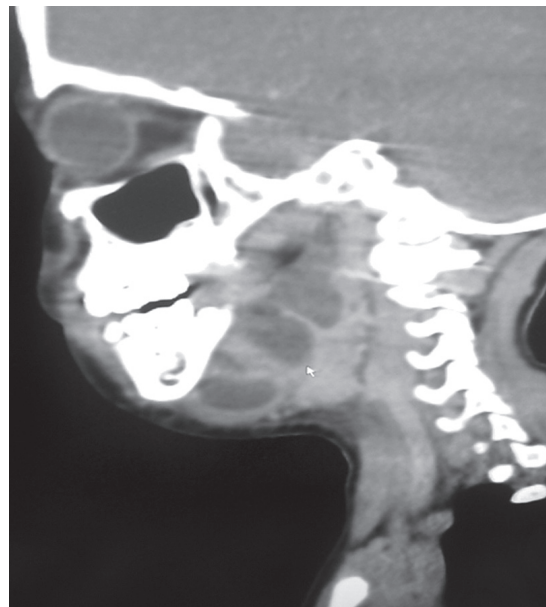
Computed tomography scan of the neck (sagittal view)
